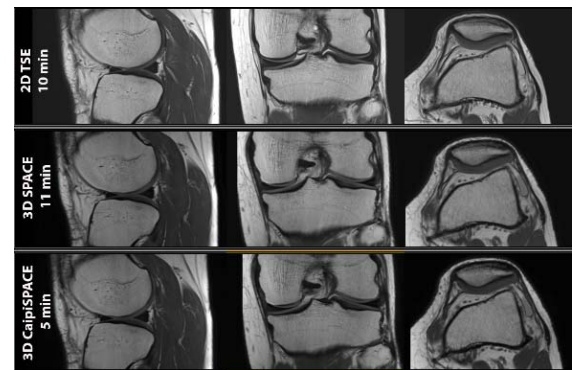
2D and 3D MRI of the knee in a 44-year-old man. Top row: sagittal, coronal, and axial 2D TSE images. Middle row: sagittal, coronal, and axial SPACE (PAT2) reconstructions. Bottom row: sagittal, coronal, and axial CAIPIRINHA SPACE (PAT2x2 – shift 1) reconstructions.
